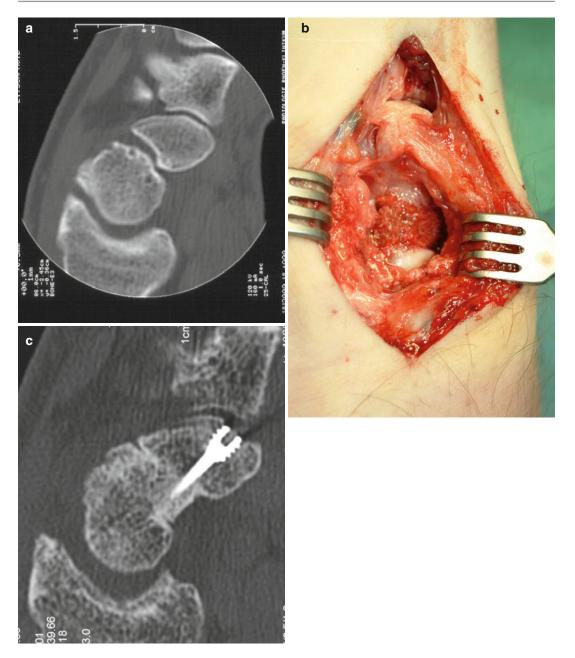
(a) Scaphoid non-union with humpback deformity (b) Reconstruction with large bone graft (c) Confirmation of healing by CT scan
